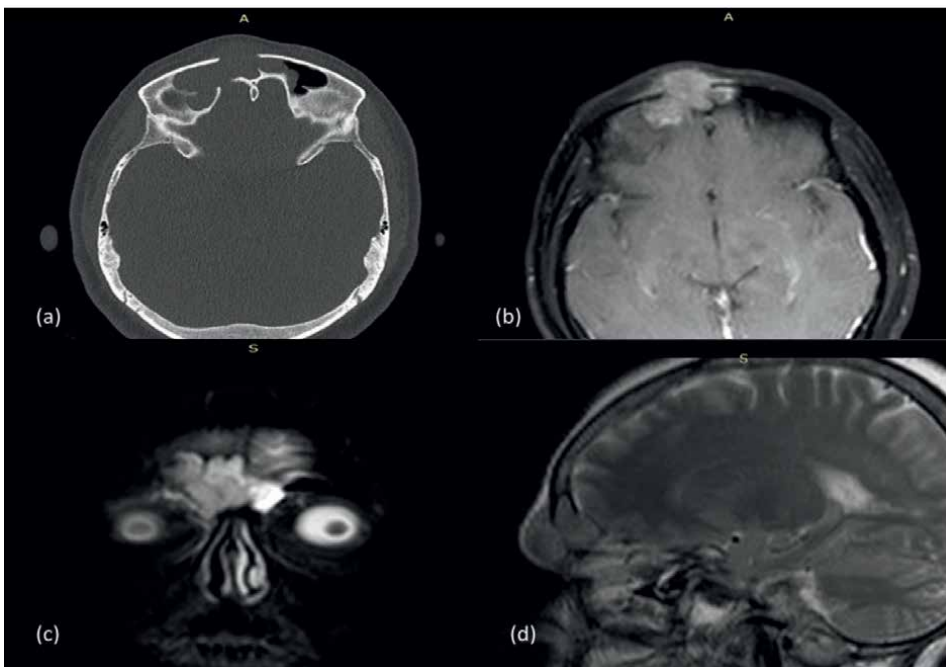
(a) axial CECT bone window showing erosion of anterior and posterior table of frontal sinus (b) axial CEMRI T1 W showing enhancing tumor (c) coronal T2W MRI (d) sagittal T2W MRI.
